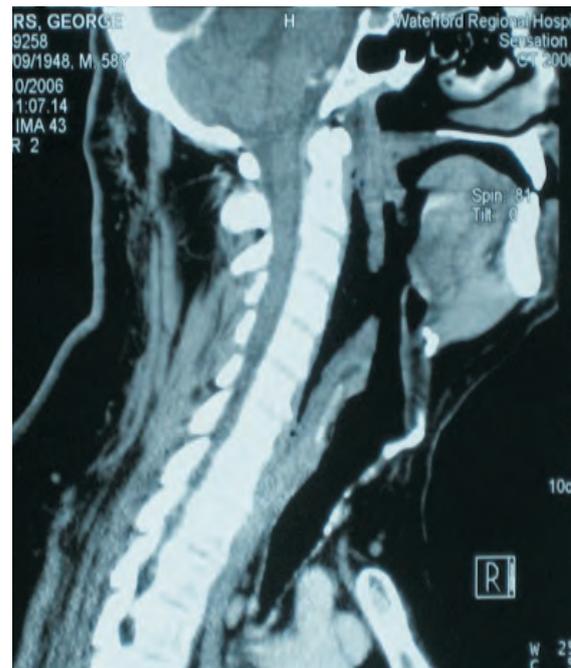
Sagittal CT Neck showing gross prevertebral tissue swelling from the level of oropharynx to the cricoids cartilage. A 10cm defect posterior pharyngeal wall (arrow)
